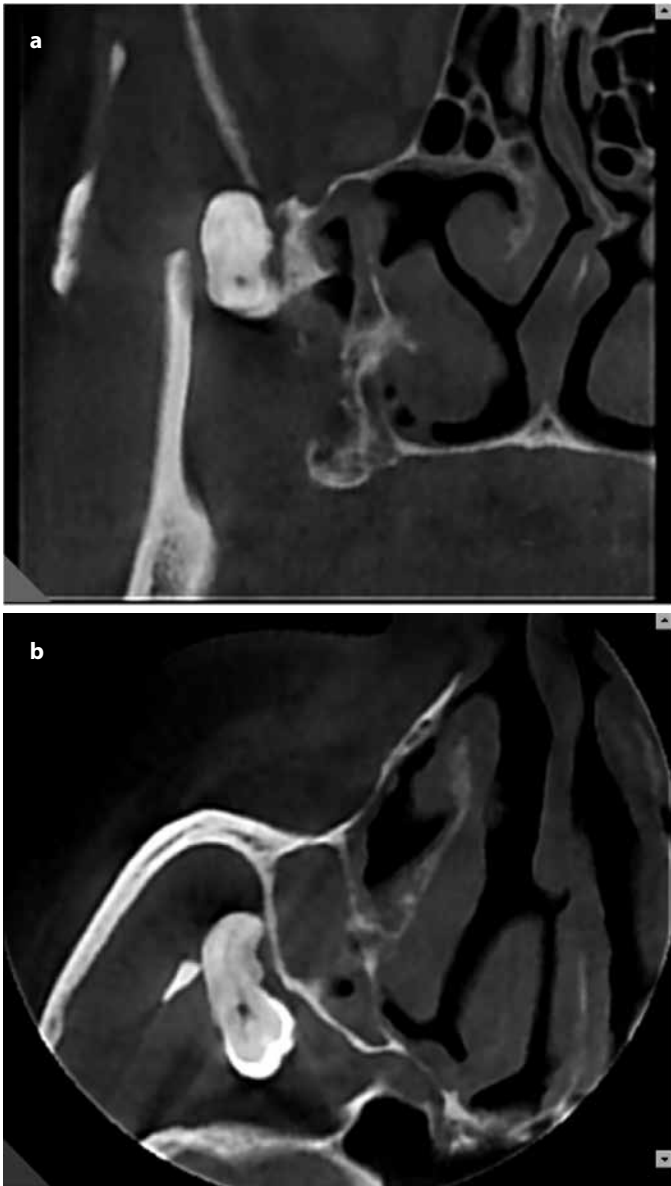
a, b. (a) Coronal view of displaced tooth in cone beam computed tomography. Note the displaced tooth between lateral superior wall of maxilla and coronoid process of mandible. (b) Axial view of displaced tooth in cone beam computed tomography.
